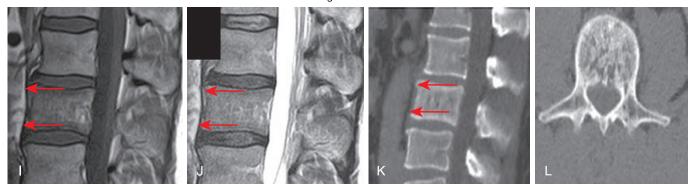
cont'd Images I through L are from a 67-year-old male with Paget disease of bone. The affected vertebral body is heterogeneously hypointense on T1 (I) and hyperintense on T2 (J). Sagittal MRI (I and J) and sagittal and axial CT (K and L) images demonstrate the classic triad of Paget disease: thickened cortex (arrows), thickened trabecula, and wide bone (notice the vertebral body is slightly larger than those adjacent).
